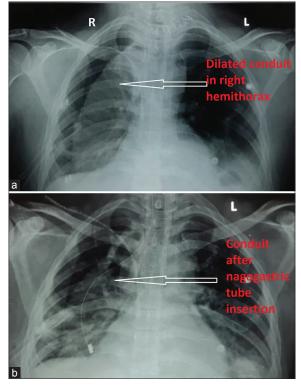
(a) Chest radiograph showing grossly dilated gastric conduit in the right hemithorax. (b) Chest radiograph after nasogastric tube placement showing a decompressed conduit due to which the patient improved symptomatically
